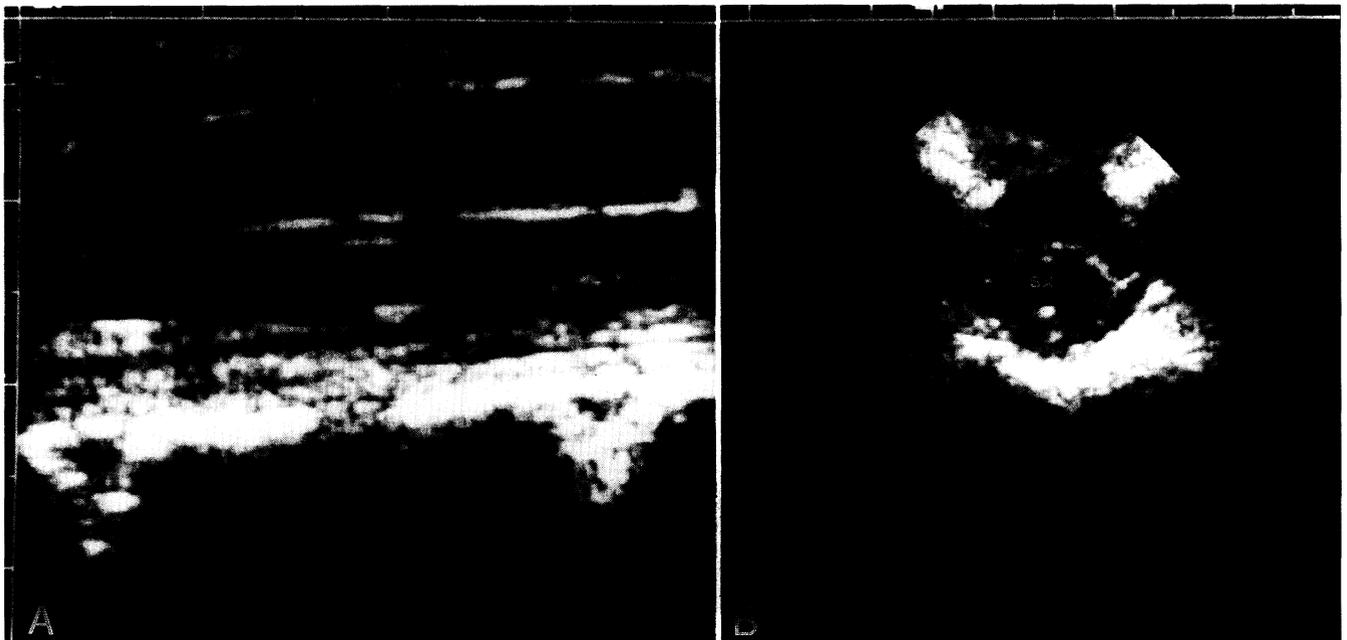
Longitudinal (A) and transverse (B) intraoperative sonograms of the syrinx. Note the cystic dilatation of the central canal (sx). Subsequently, drainage tube was placed and decompression of the syrinx was documented sonographically.
